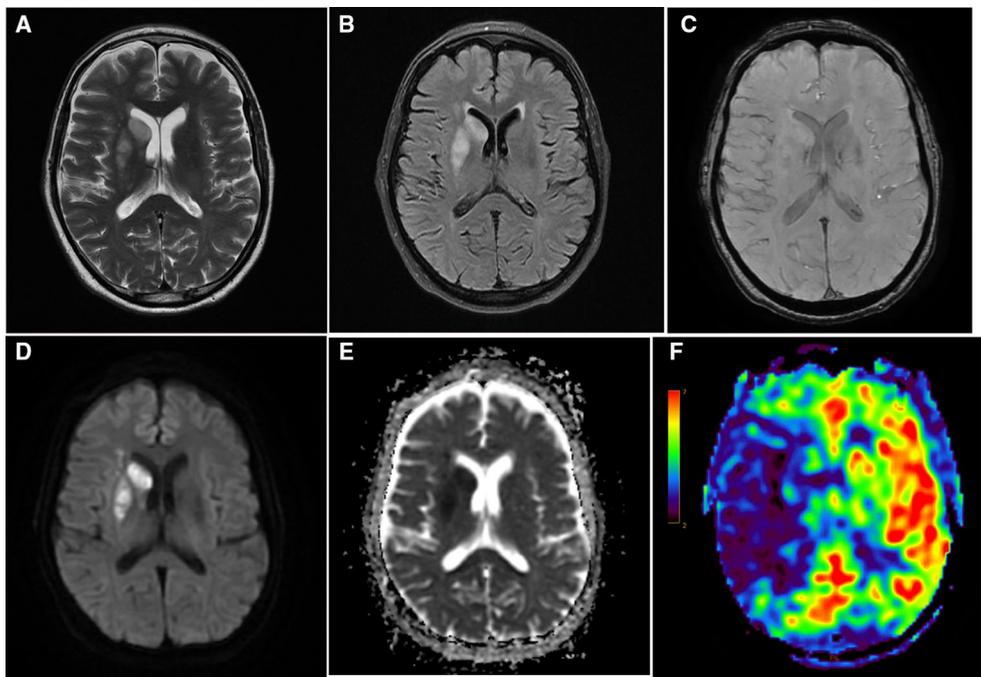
Acute infarction with ischemic penumbra: 78 years old male patient complaining of left hemiplegia since 8 h. A T2WI, B FLAIR, C SWI, D DWI, and E ADC map show acute ischemic infarct at the right basal ganglia. ASPECTS score was 8/10. F ASL perfusion at 1.5 s shows larger area of hypo perfusion (diffusion perfusion mismatch) reflecting large area of ischemic penumbra, $aCBF = 14 \text{ mL/gm } 100/\text{min}$ — $rCBF = 65\%$ to contralateral side. $aCBF$ absolute cerebral blood flow, ADC apparent diffusion coefficient, ASL arterial spin labeling, $ASPECT$ Alberta Stroke Program Early CT Score, DWI diffusion weighted image, $rCBF$ relative cerebral blood flow, SWI susceptibility weighted image
